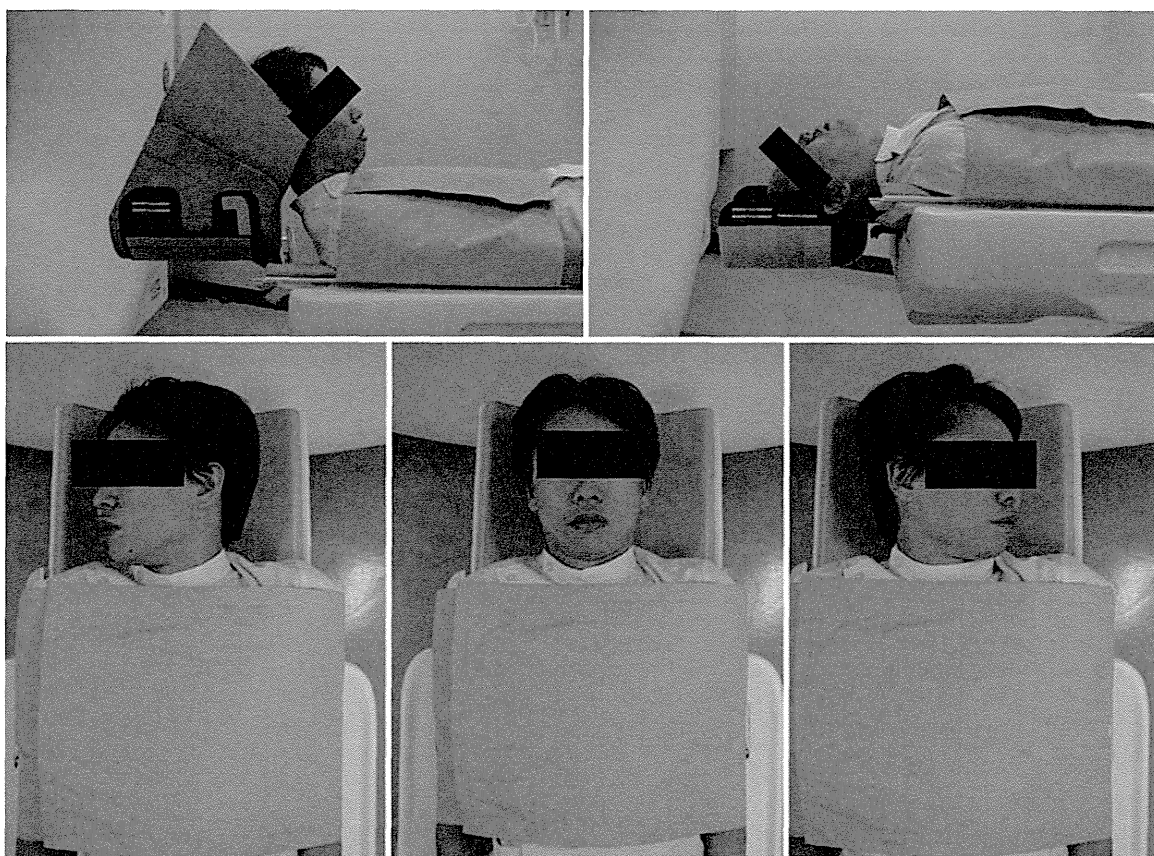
Acquisition of CT scans of maximum AP flexion and maximum axial rotation. The examiner was instructed to help participants bend their necks until they could rest their chin on their chest with the use of a supportive device in anterior flexion without pain or discomfort, and to have participants rotate their head perpendicular to the axis of their body trunk.
